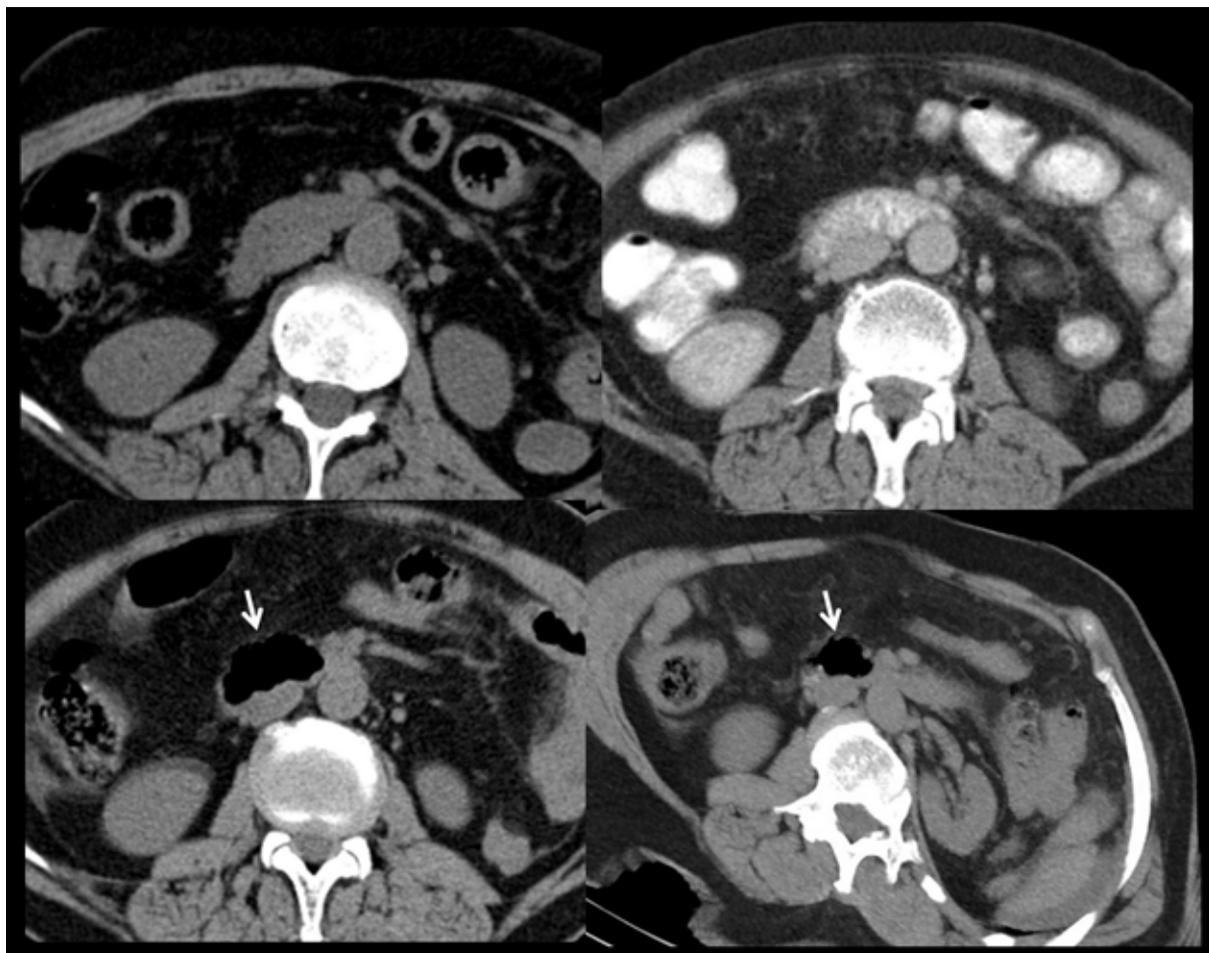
Axial CT images of the same patient at different time points. Duodenal diverticulum (*arrow*) arising from the third portion of the duodenum is seen only in a single CT study (*arrows in axial and reformatted unenhanced CT images*) suggesting that duodenal diverticulum may not always be apparent on CT images.
